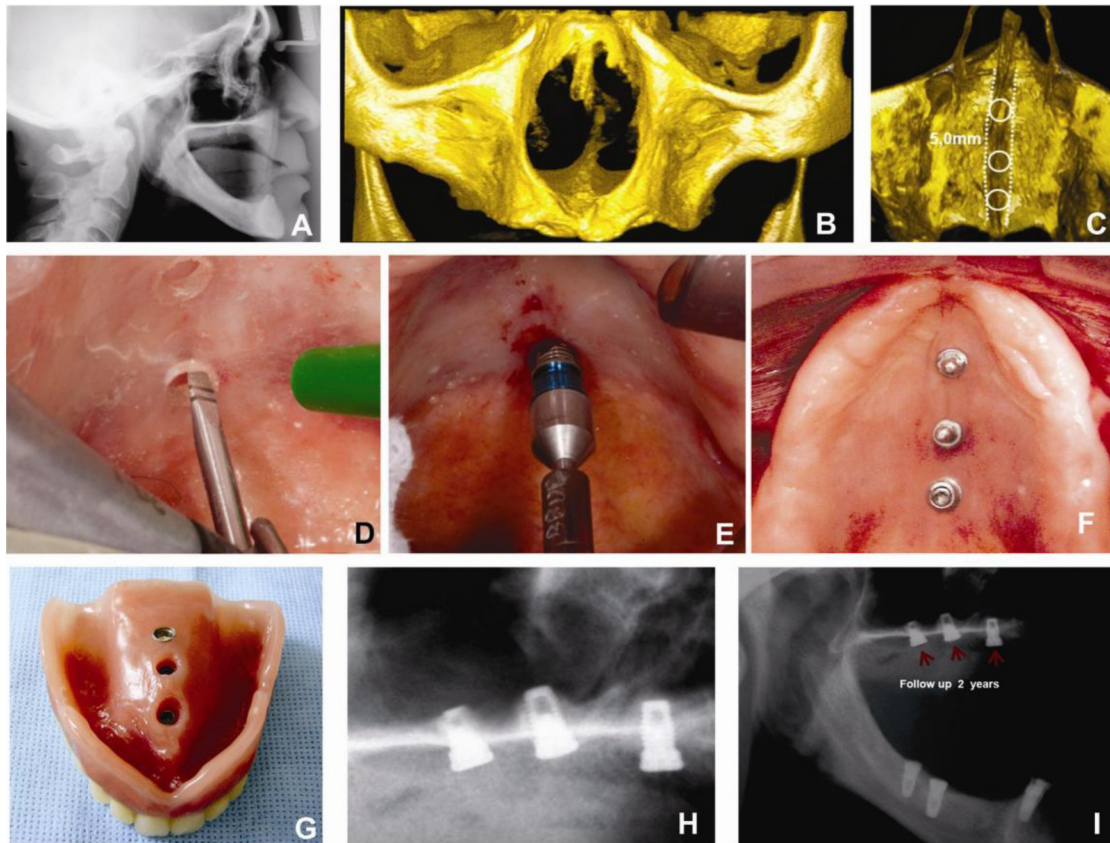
(A) Preoperative telerradiography; (B) and (C) preoperative computerized tomography; (D) perforation to allow fitting of the implants; (E) fitting of the implants; (F) implants in place; (G) implant–mucosa-supported prosthesis; (H) and (I) follow-up radiography at 2 years.
